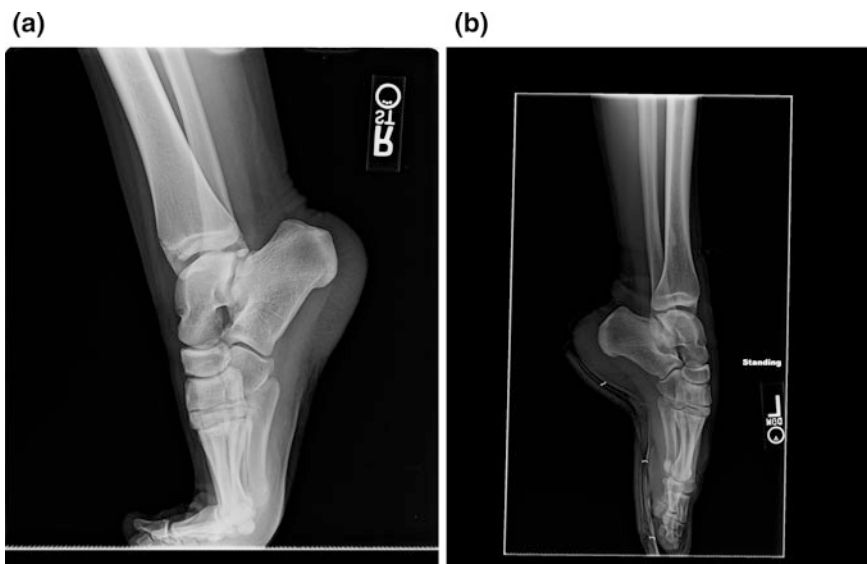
a Radiograph of a 13-year-old dancer with posterior impingement and a painful os trigonum. Note that the dancer is unable to achieve full demi-pointe position with weight bearing (i.e., she is unable to align her metatarsals under the tibia or get maximal ankle plantarflexion). b Radiograph of a 15-year-old dancer demonstrating the “en pointe” position of the foot. Although this dancer has a prominent Steida process, she had no impingement symptoms at the time of the radiograph, and could easily achieve maximal ankle plantarflexion
